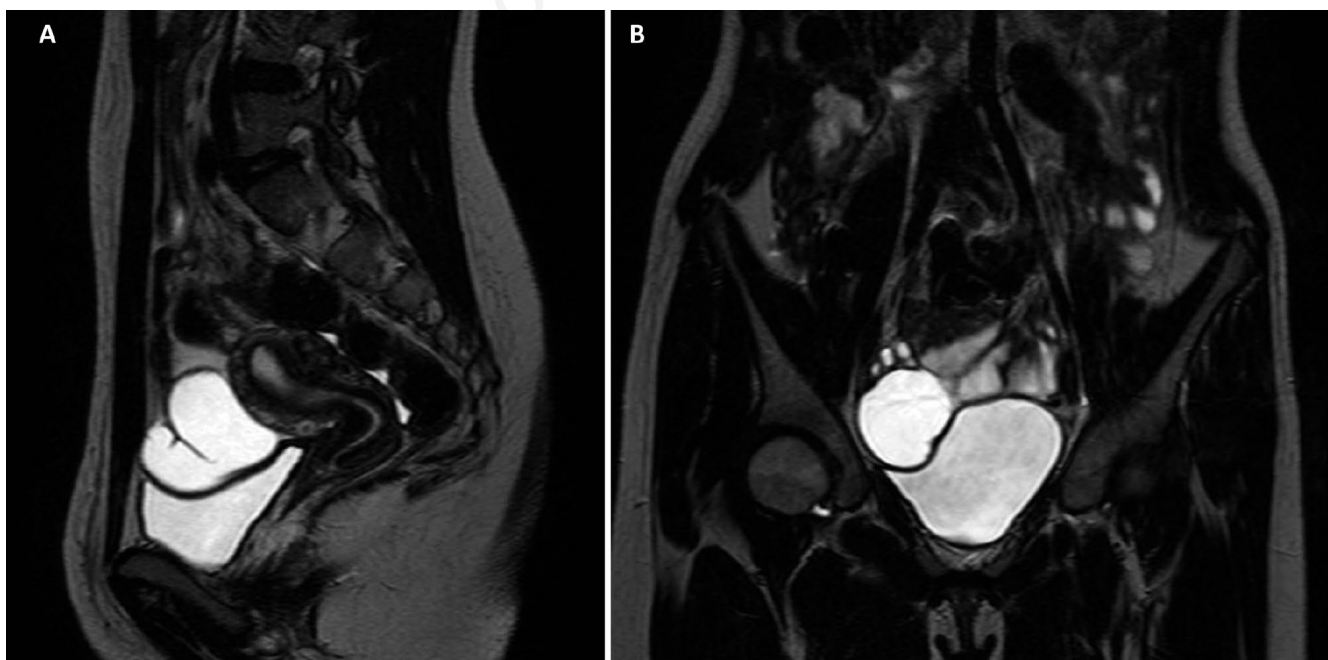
Case 2: A) transverse and B) sagittal section of T2W-MRI scan of right fluid-filled S-shaped Fallopian tube.
